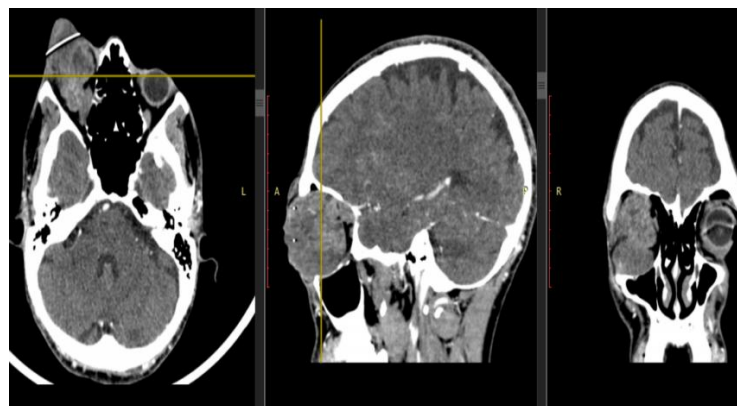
Pre and post contrast brain CT scan, 2025.
